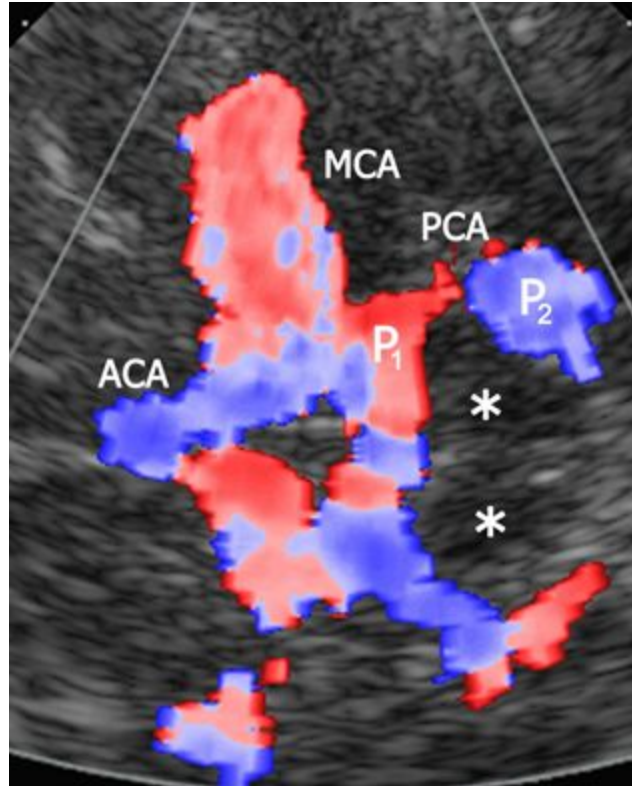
Transtemporal color Doppler image of the circle of Willis. * indicates cerebral peduncle.
